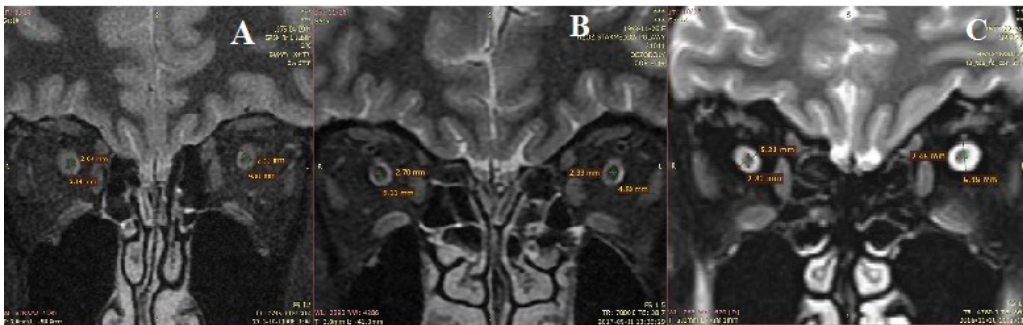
Constructive interference in steady state T2-weighted sequences imaging (CISS MRI) for the three patients. A. Case 1; B. Case 2; C. Case 3
